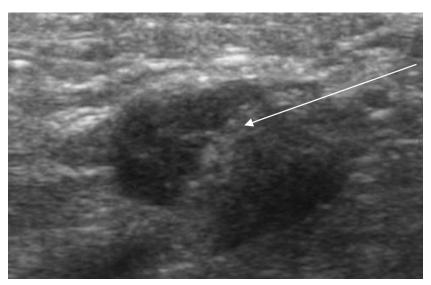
Sonographically guided interdigital neuroma injection, long axis to neuroma, needle approach in plane with transducer. Arrow delineates path of needle. Left, proximal; right, distal.
